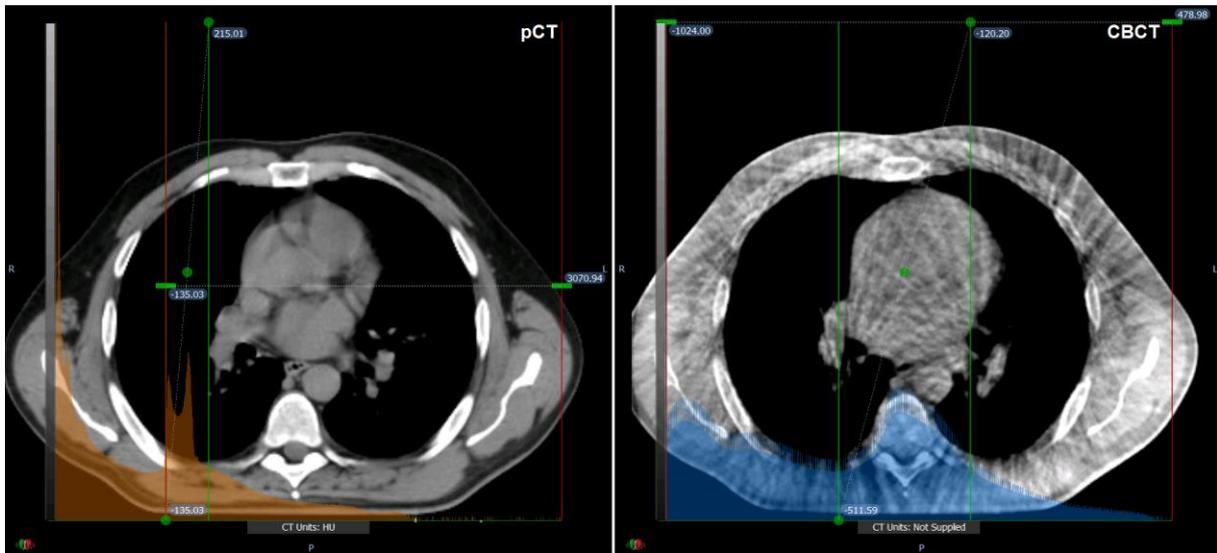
Window width and window level settings for pCT (left) and CBCT (right). The pCT has a WW/WL of 350/40. The CBCT has a WW/WL of 380/-315. The poorer image quality of CBCT is clearly visible, showing streak artifacts and a lower spatial resolution.
